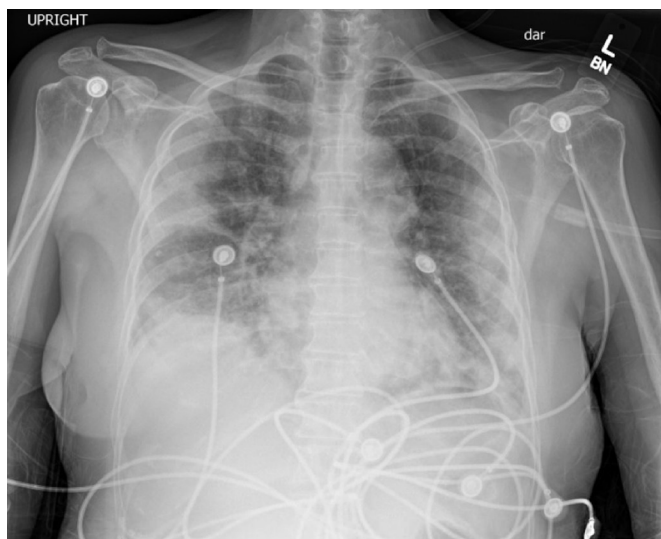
Chest X-ray showing multifocal bilateral patchy opacities with confluent opacities in the right upper lobe.
